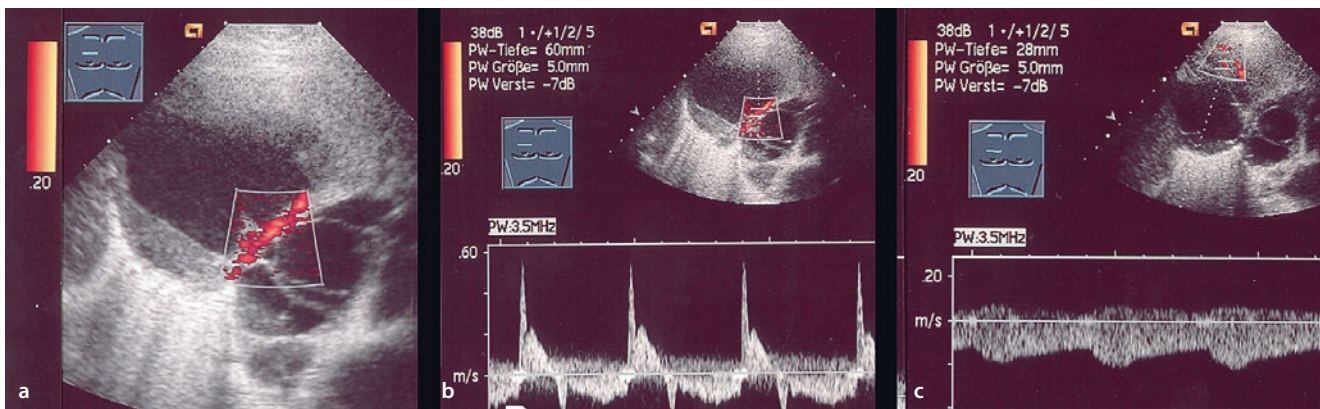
A 44-year-old man with sarcoma of the lung. a Color-Doppler sonography shows a tumor with solid and cystic portions and vessels in the seventh course. b Spectral curve analysis
